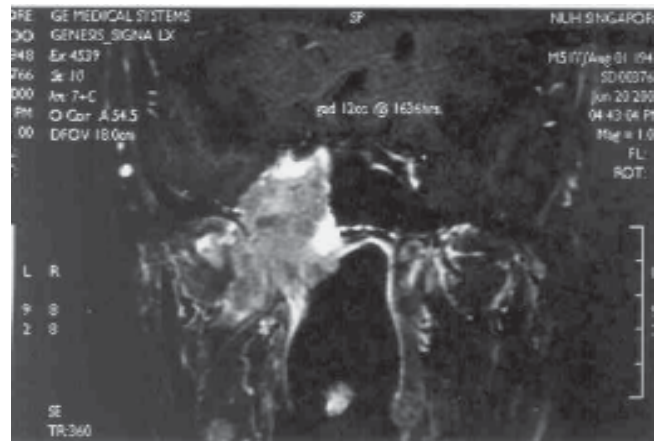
MRI showing an abnormal mass in the right sphenoid invading the cavernous sinus encasing the right internal carotid artery, indicative of tumour progression.
